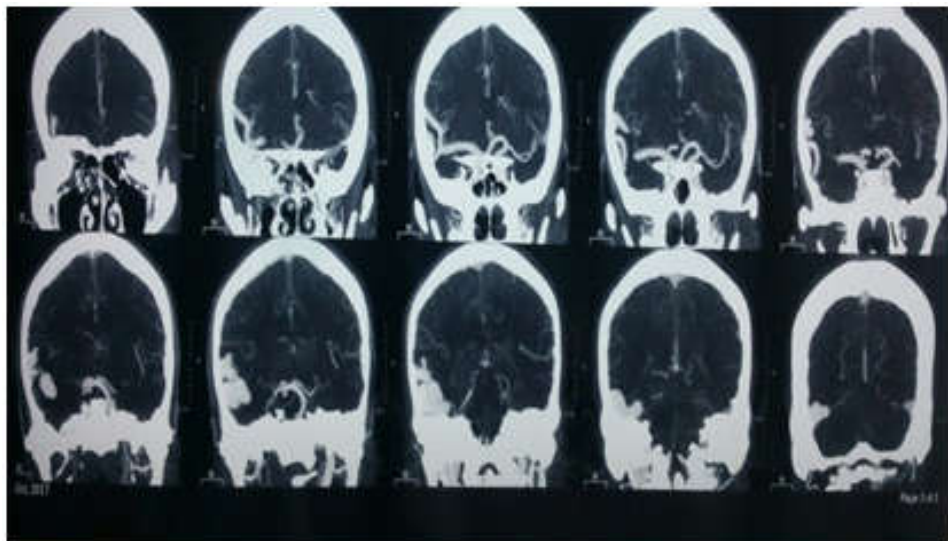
(b): CT Angiogram showing Pial Arteriovenous fistula with Right middle cerebral artery feeders and drainage into vein of Labbe.
